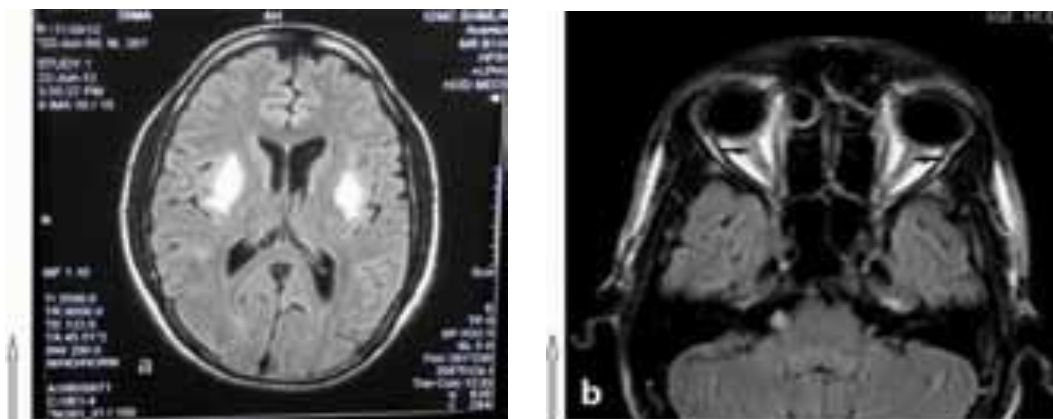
a and b. Axial FLAIR MR images of brain (a) showing hyperintensities suggesting bilateral putaminal hemorrhagic necrosis and linear hyperintensities (*arrows*) in intraorbital parts of bilateral optic nerves (*magnified view*, b) suggesting atrophy
